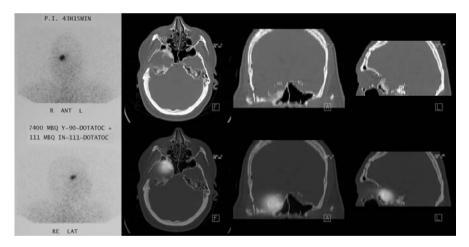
Patient with meningioma. Irradiation with 111 In- / 90 Y-DOTATOC. Planar scintigraphic imaging on the left side, SPECT/CT fusion imaging on the right side of the picture.
